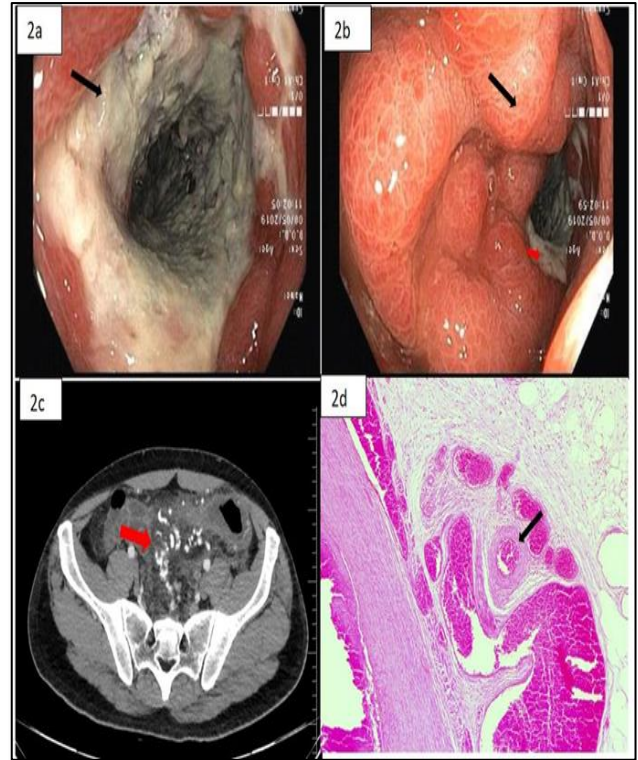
(A-D): Colonoscopy picture showing necrotic mucosa of descending colon, normal mucosa with transition to necrosis (red arrow), CT scan arterial phase axial section showing AVM (arrow); and HPE low power showing multiple submucosal vascular channels (arrow).
